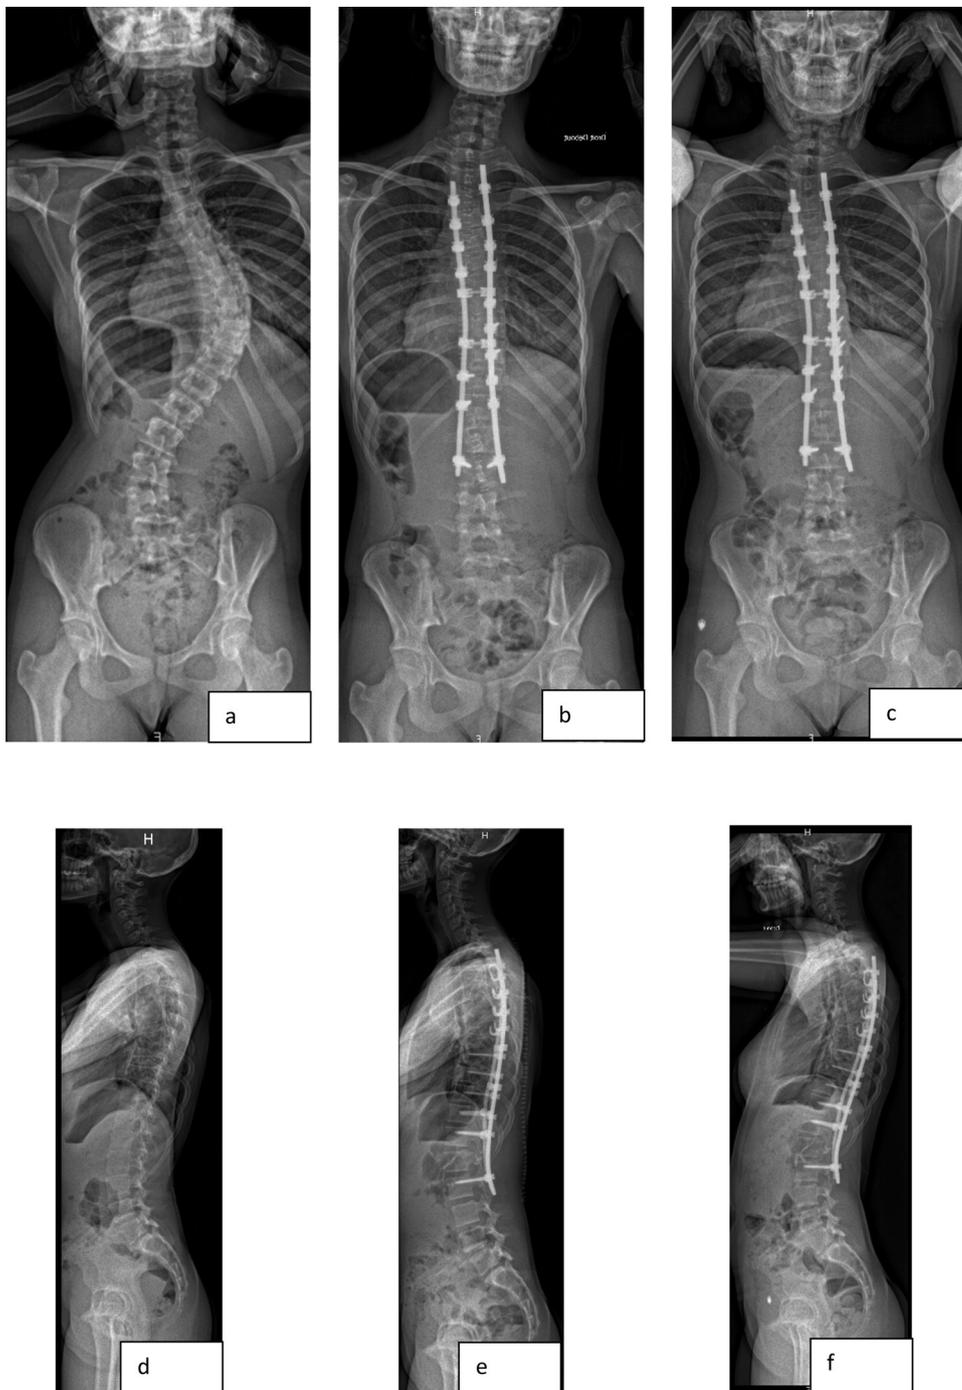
Female patient aged 14 years at surgery. Antero-posterior radiographs before surgery (a), 7 days after surgery (b), and 26 months after surgery (c). Lateral radiographs before surgery (d), 7 days after surgery (e), and 26 months after surgery (f).
